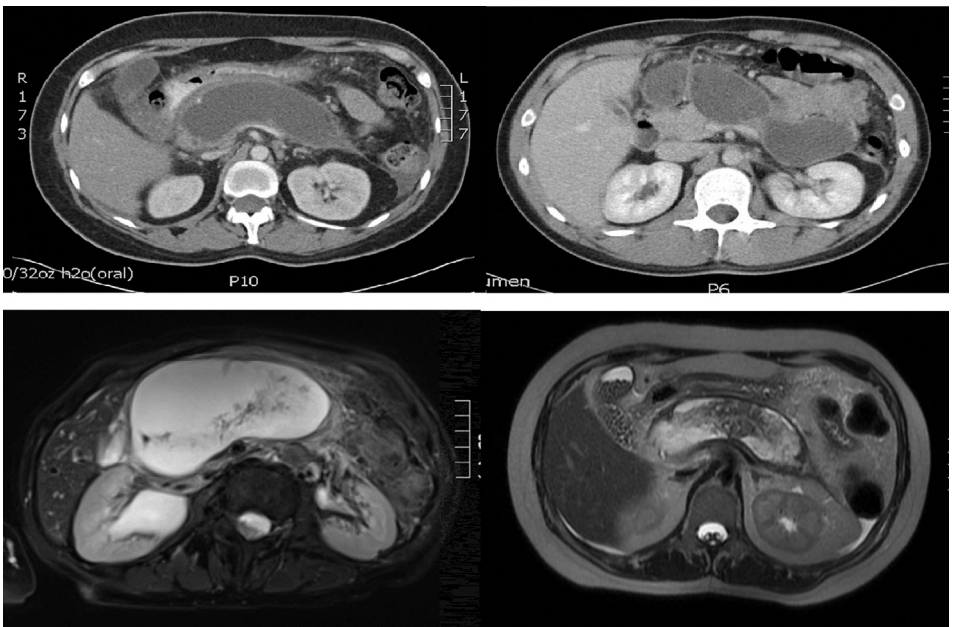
Walled-off pancreatic necrosis on enhanced CT (upper panels) and T2-weighted MRI (lower panels).
